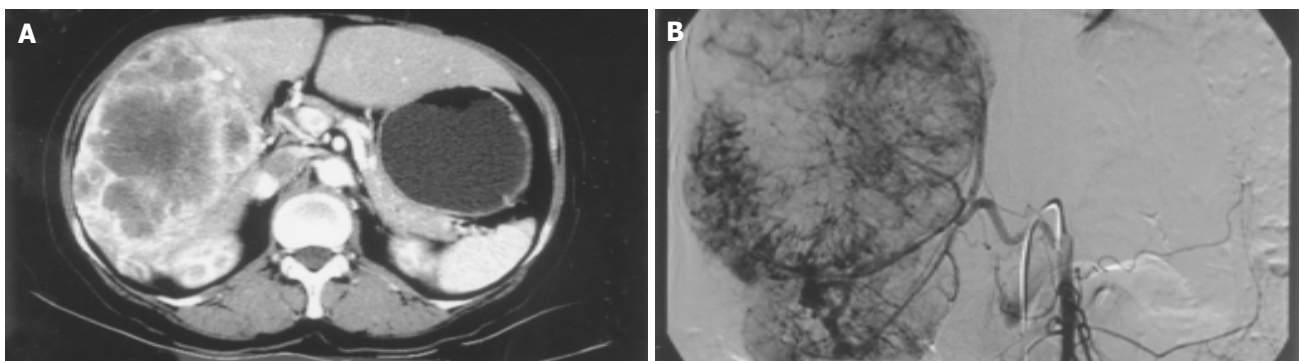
A: Liver CT scan showed a huge tumor in the right lobe of the liver with enhancement from the periphery in the arterial phase; B: The hepatic arteriogram
